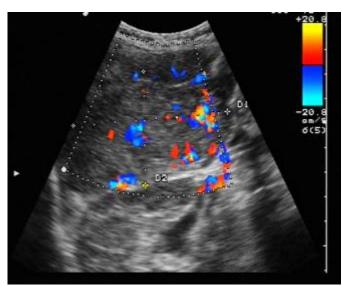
A 50-year-old woman with hepatocellular carcinoma. Color Doppler shows remarkable intratumoral vascular flow.
